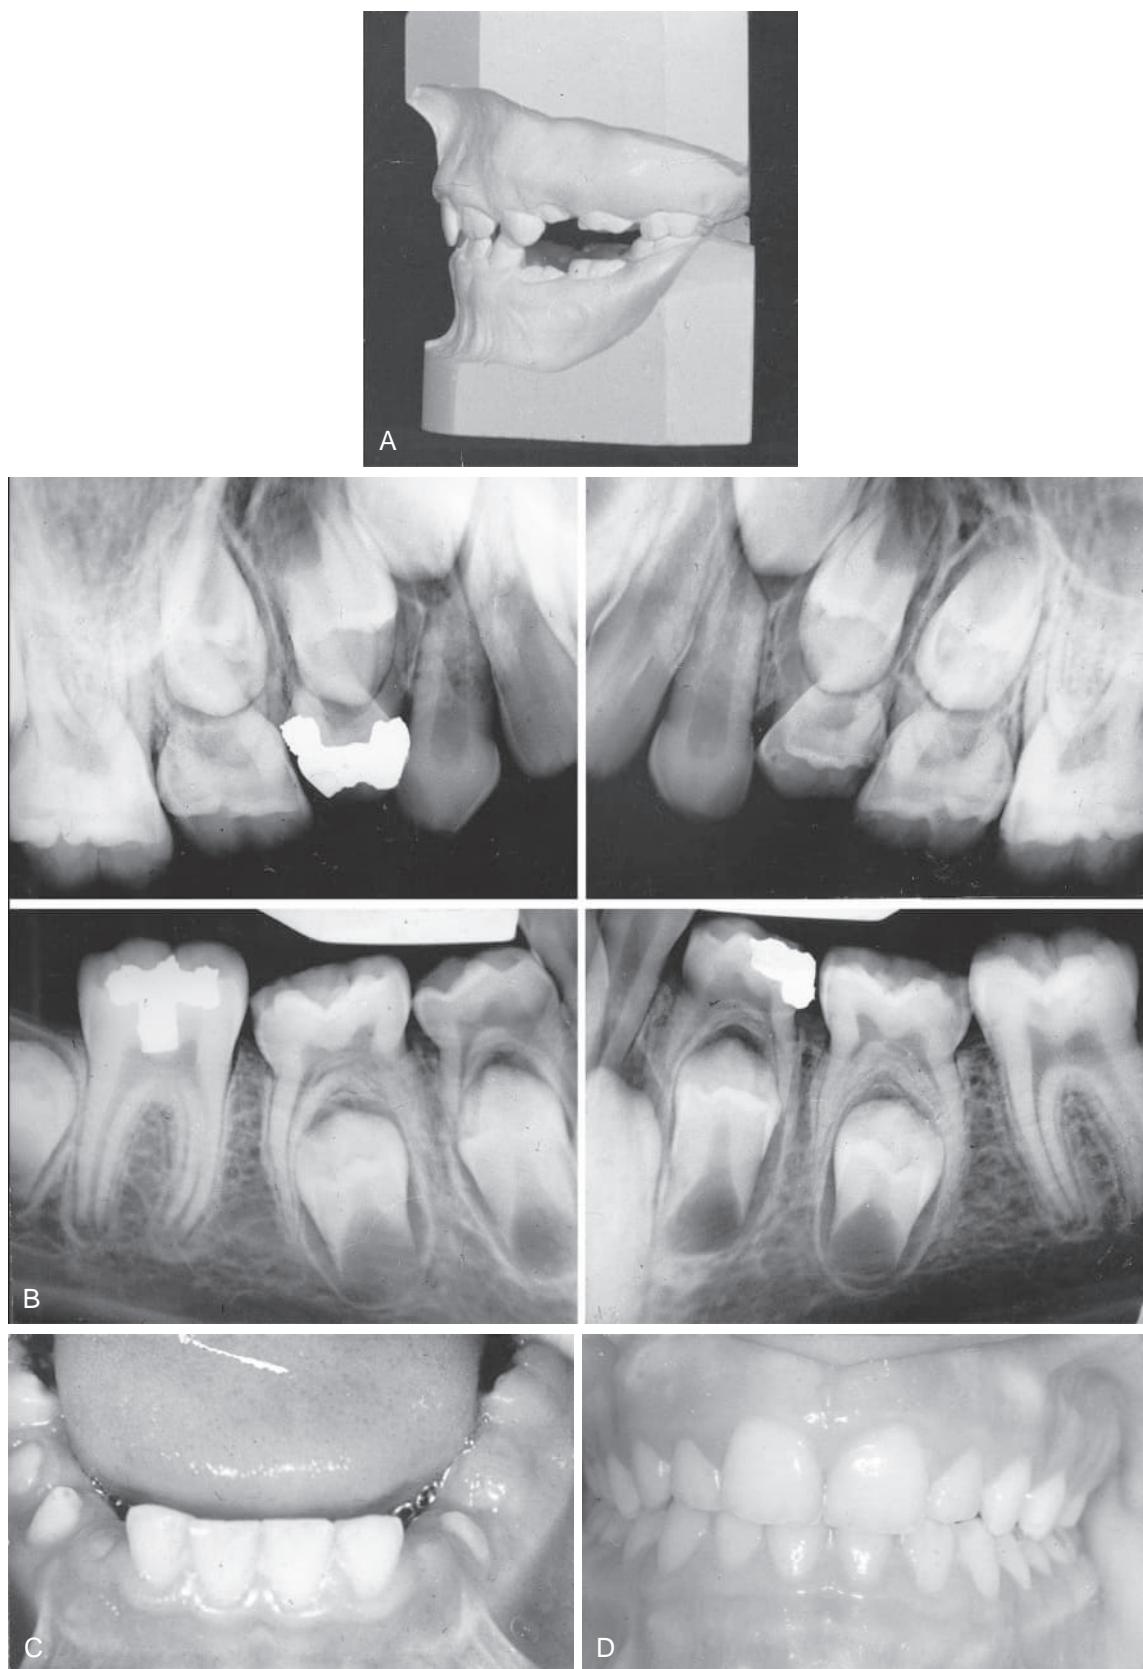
(A) All eight of the primary molars were ankylosed. Continuing eruption of the adjacent teeth has caused a loss of arch length. (B) Radiographs aided in the diagnosis of the ankylosed primary molars. The recommended treatment was surgical removal of the ankylosed teeth. (C) Space maintainers were constructed after removal of the ankylosed teeth and were worn until the permanent teeth erupted. (D) Ideal occlusion was achieved as a result of early diagnosis and the removal of the ankylosed teeth at the proper time.
